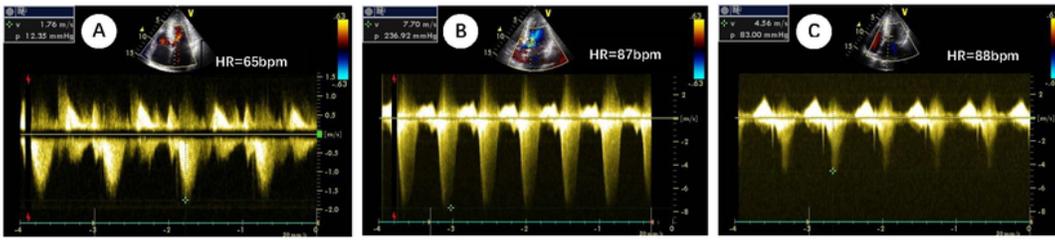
A: Left ventricular outflow tract gradient after treatment, 12.35mmHg. B: Gradients in the left ventricular outflow tract (CW-Doppler) at provocation of isoproterenol before ERASH, 60 mmHg, HR 87bpm. C: Gradients in the left ventricular outflow tract (CW-Doppler) at provocation of isoproterenol after ERASH, 83 mmHg, HR 88bpm.
